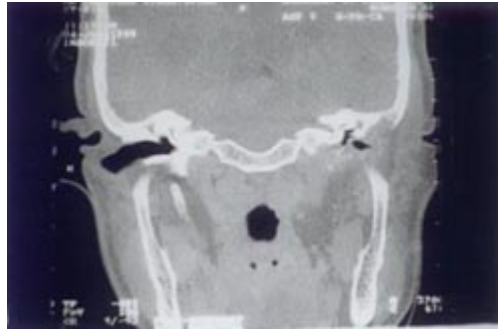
The CT Scan of the patients left temporal bone showing destructive lesion involving left temporal bone, mastoid and styloid process
